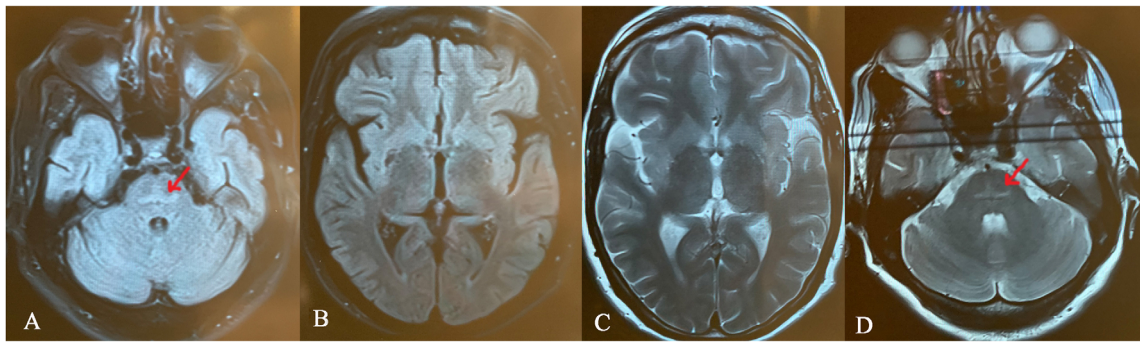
Axial fluid-attenuated inversion recovery (FLAIR) and T2 brain magnetic resonance imaging (MRI) shows hyperintensity of basal ganglia and pons.
